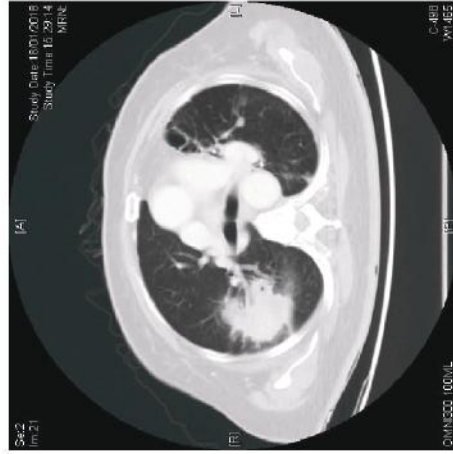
CT thorax in second hospitalization
